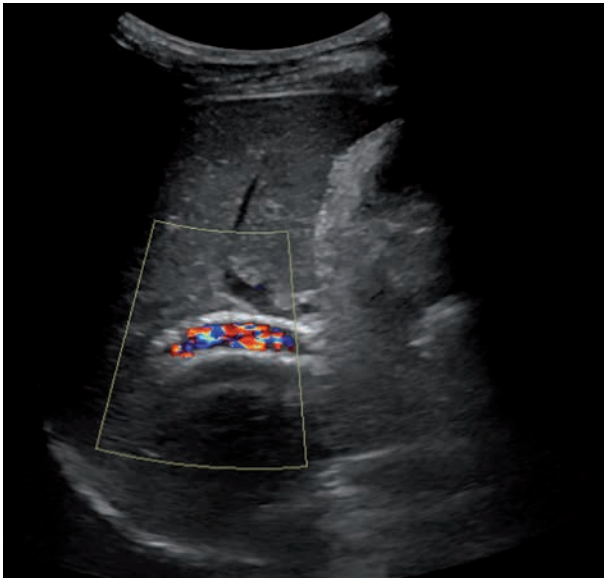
Colour Doppler ultrasound shows excellent flow through the TIPSS one-month post-Trellis thrombectomy.
